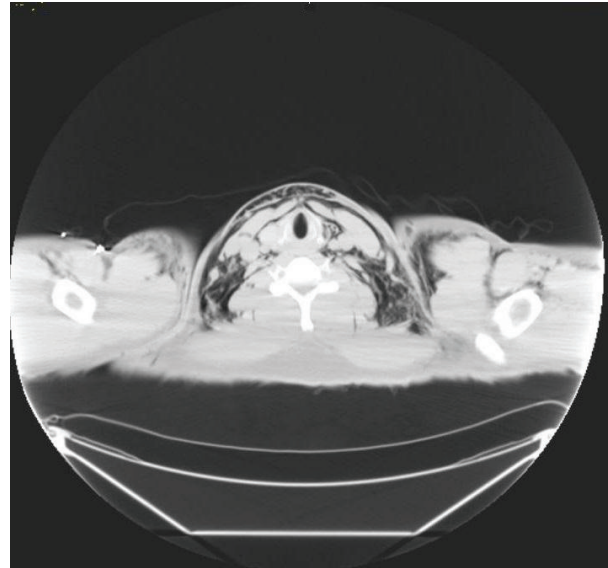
Axial view of CT chest revealing cervical and facial subcutaneous emphysema.
